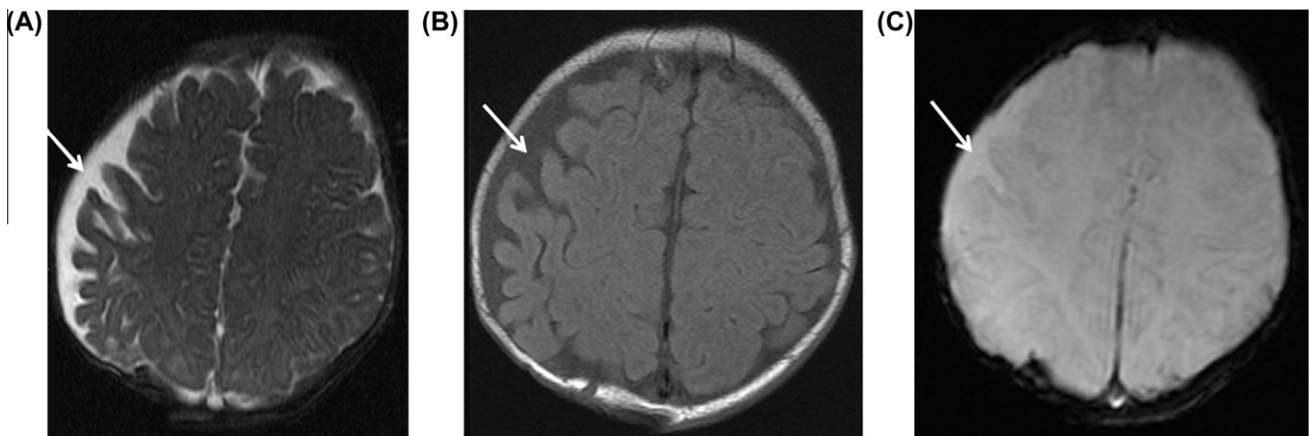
Axial images of a 3-month-old female with a history of traumatic brain injury, 2 months after right decompressive craniotomy and evacuation of a subdural hematoma (Patient 7). (A) Fast Imaging Employing Steady State Acquisition brain MRI showing dilatation of extra-axial cerebrospinal (CSF) spaces at the craniotomy site (arrow). The CSF spaces were increased in size in comparison to a previous study (not shown); however, we were unable to rule out or confirm new bleeding. (B) T1-weighted MRI performed on the same date showing no evidence of bleeding (arrow). (C) Gradient echo sequence on the same date showing that a blooming artifact, suggestive of blood products, is not seen (arrow).
